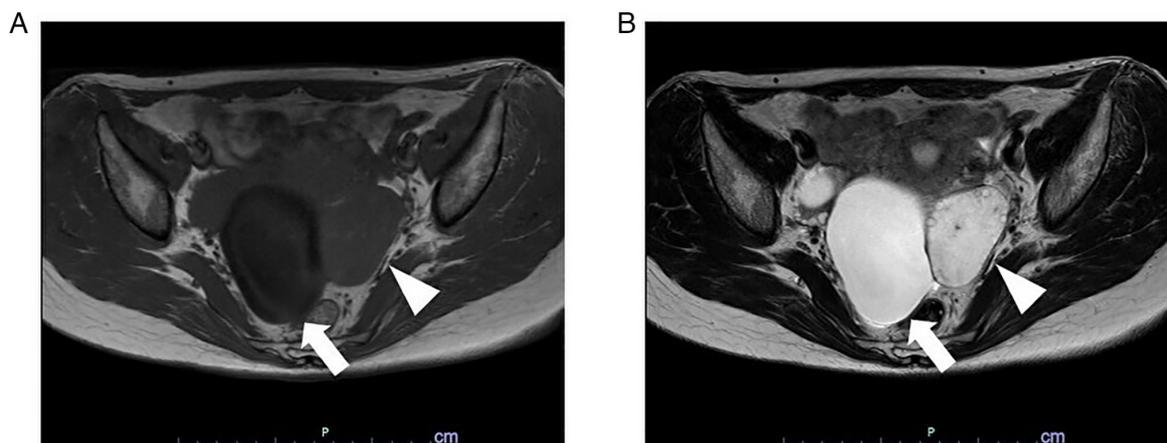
Preoperative MRI examination. (A) T1-weighted and (B) T2-weighted axial images. A 55-mm lesion with multiple peripheral ovarian follicles, which was isointense on T1-weighted images and hyperintense on T2-weighted images, and a 75-mm cystic lesion without a solid component, which was hypointense on T1-weighted images and hyperintense on T2-weighted images, were identified in the left adnexa. The right ovary was normal, exhibiting only a small functional cyst. The white arrows indicate the left paraovarian cyst. The white arrowheads indicate the left ovary.
